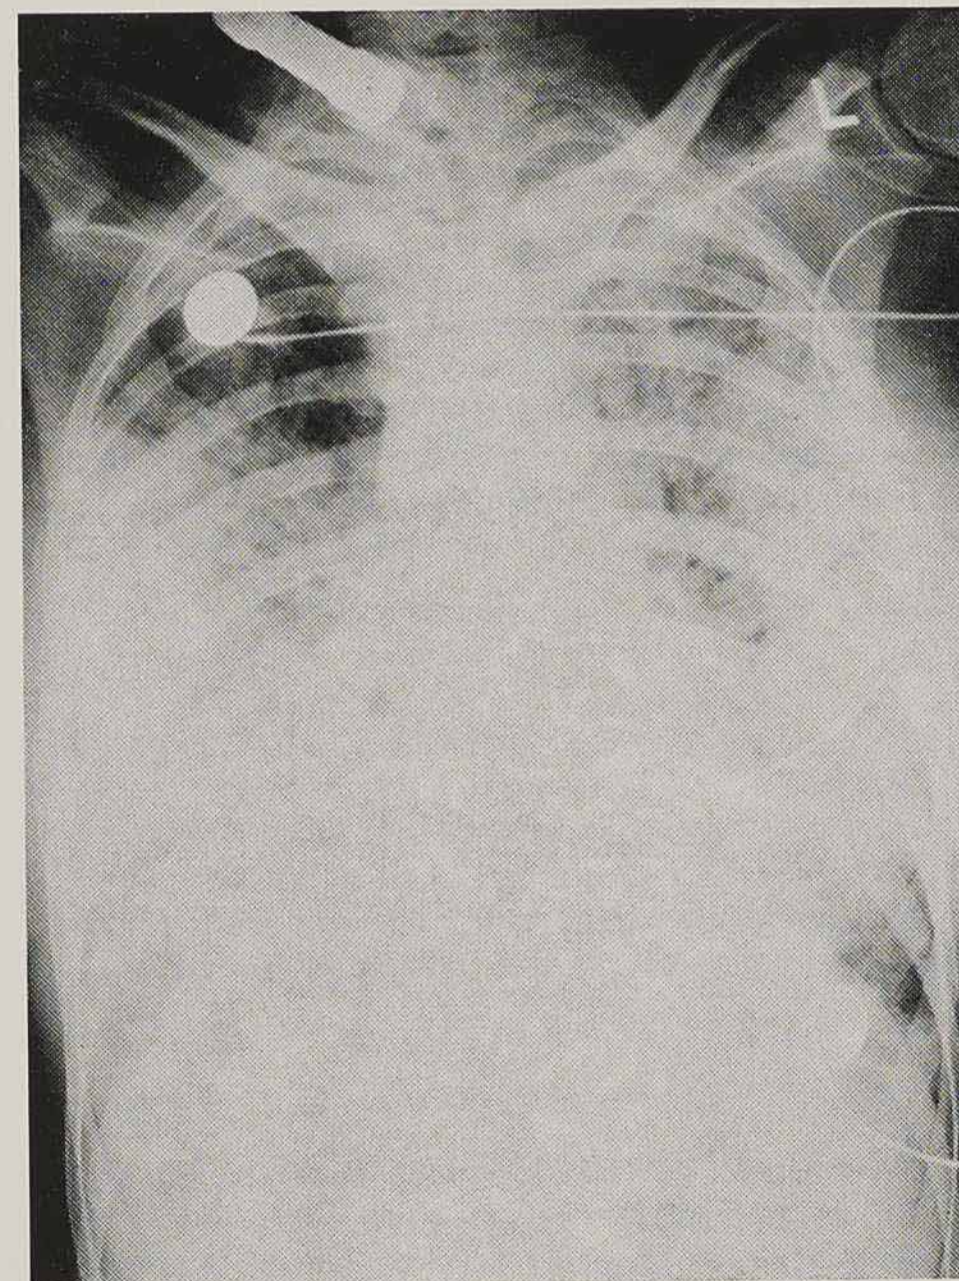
Chest x-ray film showing interstitial pulmonary oedema following bomb blast.
